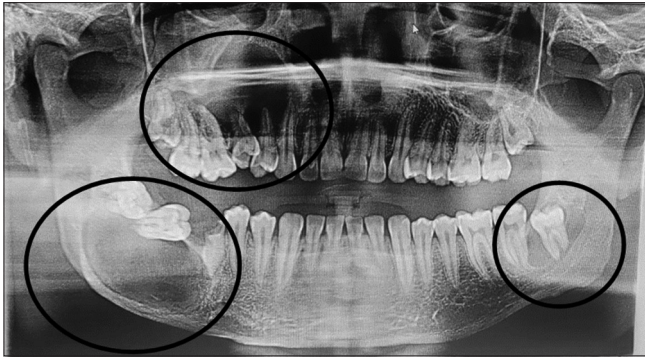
Orthopantomogram (OPG) showing multiple cystic lesions
